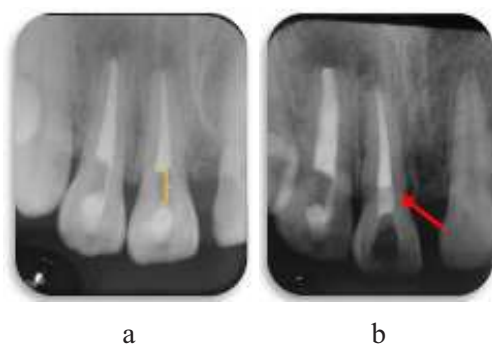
a. Gutta percha removal evaluation. Periapical radiograph showed void area after removal at the cervical level (yellow line)b.Periapical Radiograph of Tooth 11 after cervical barrier placement (red arrow).
